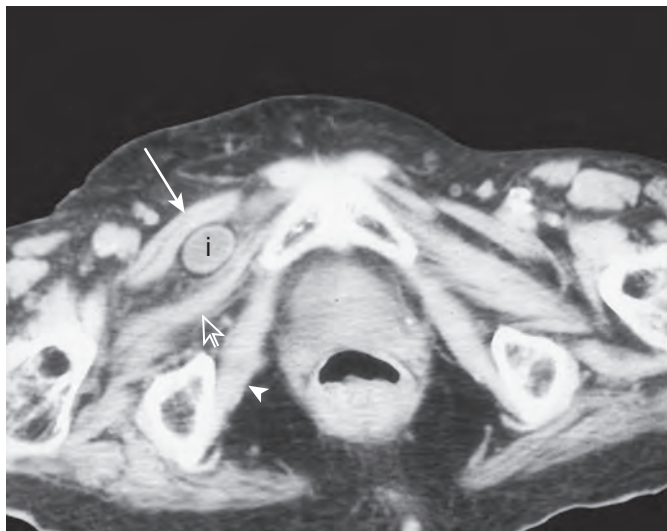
Obturator hernia. Axial CT scan through the pelvis shows a loop of ileum (i) between the pectineus muscle (large arrow) and the external obturator muscle (short arrow). The internal obturator muscle is identified by the arrowhead.
